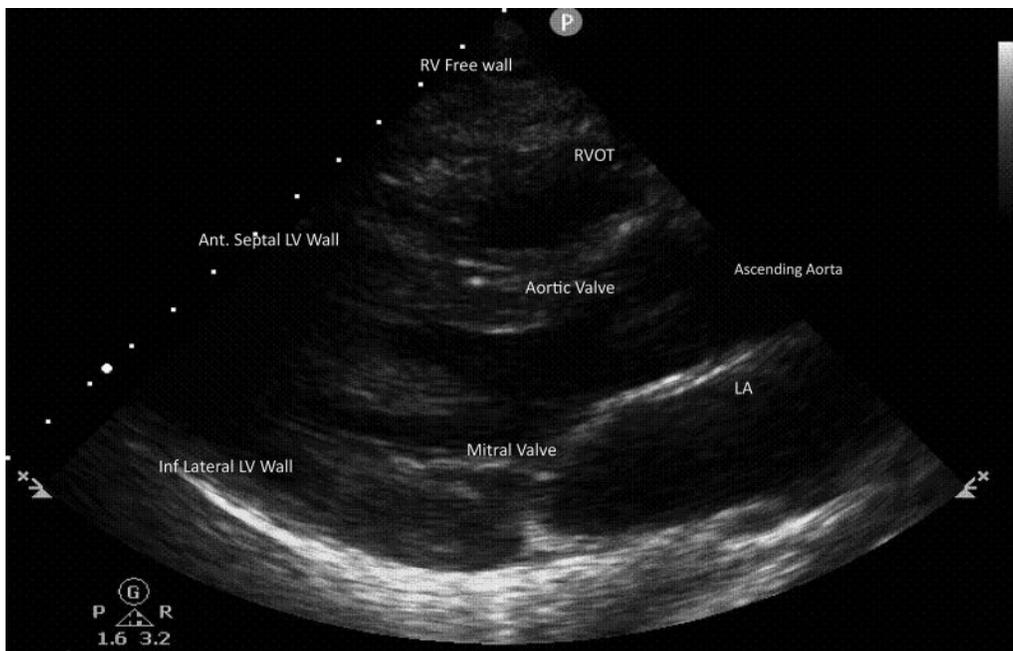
Normal parasternal long-axis (PLAX) labelled.⁴
